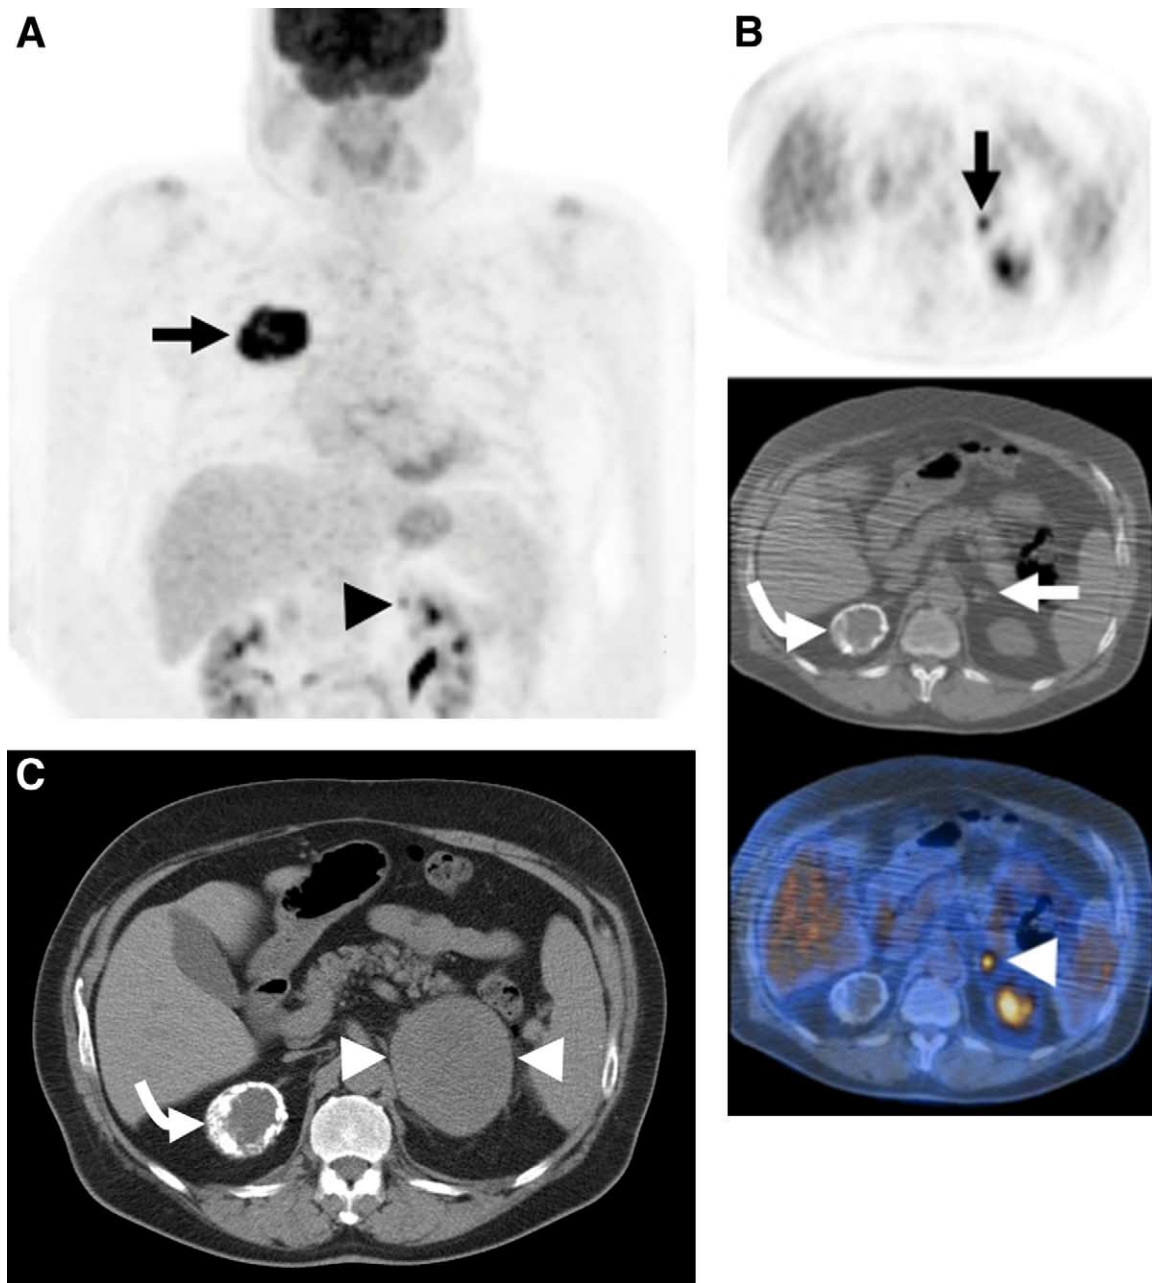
FDG-PET and adrenal metastases. A 72-year-old subject with biopsy-proven NSCLC. (A) Frontal MIP image from an FDG-PET scan showing a large, intensely hypermetabolic mass in the right upper lobe (arrow) corresponding to the patient's known cancer. A tiny focus of FDG uptake is also seen superior and medial to the left kidney, in the region of the left adrenal gland (arrowhead). (B) PET/CT images showing intense FDG uptake localizing to the left adrenal gland (arrows). A rim-calcified mass in the left adrenal gland (curved arrow) is not metabolically active, consistent with previous hemorrhage. (C) Axial image from a CT scan of the abdomen obtained approximately 8 months later showing development of a large left adrenal mass (arrowheads) consistent with metastatic disease. The benign rim-calcified mass in the right adrenal gland (curved arrow) is unchanged.
